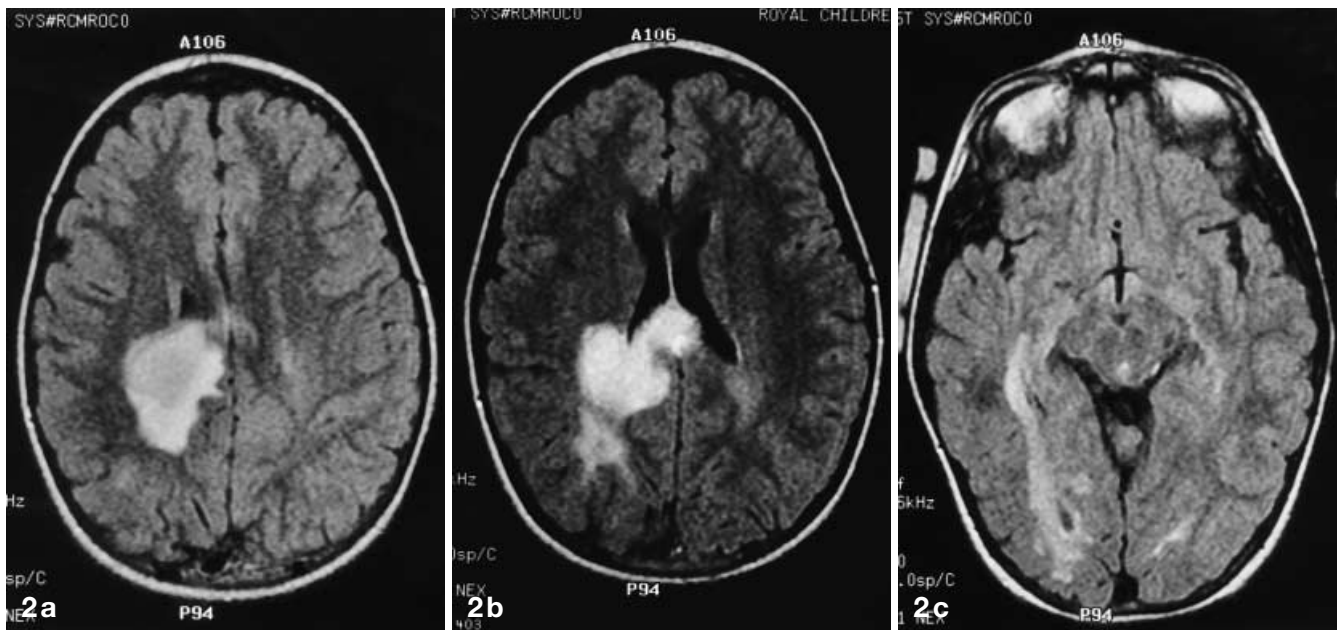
a-c Axial FLAIR MRI. a The mass shows as an extensive area of variable high signal. b There is much more extensive white matter oedema and mass effect, including involvement of the splenium of the corpus callosum than in the CT image at the same level (Fig. 1 a). c There is involvement of the right temporal lobe white matter
